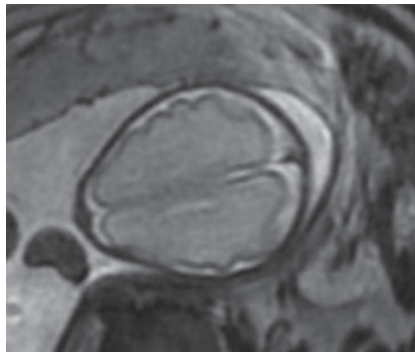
Fetal MRI at 30 postmenstrual weeks in a fetus with isolated metopic craniosynostosis.
